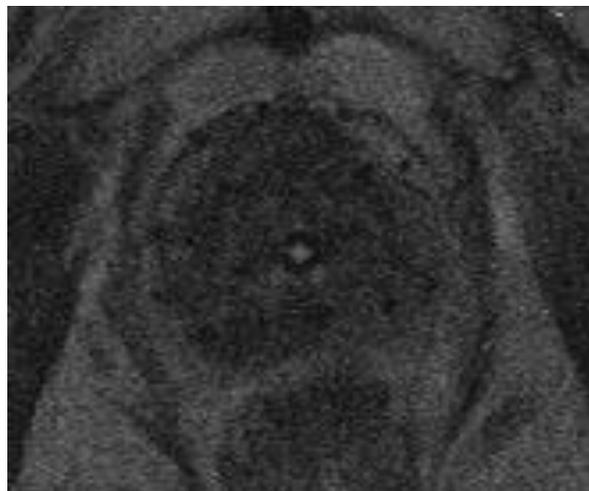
MR image from patient #5 in transverse plane towards prostate base. T2 TSE, 9670 ms TR, 104 ms TE, COL phase encoding direction, 150° flip angle, 3 mm slice thickness. Bandwidth 435 kHz.
